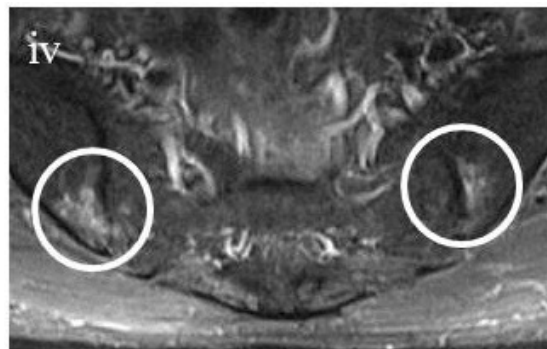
(iv): Bilateral bone edema in both sacroiliac joints detected by T2-weighted MRI with the administration of contrast material.
